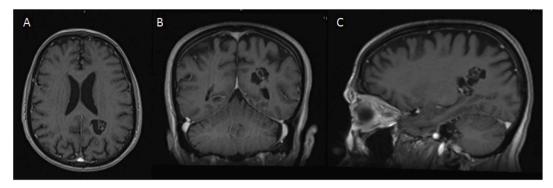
Axial (A), coronal (B) and sagittal (C) T1-weighted gadolinium enhanced MRI (magnetic resonance imaging) showing a 27 mm polycystic left parietal mass.
